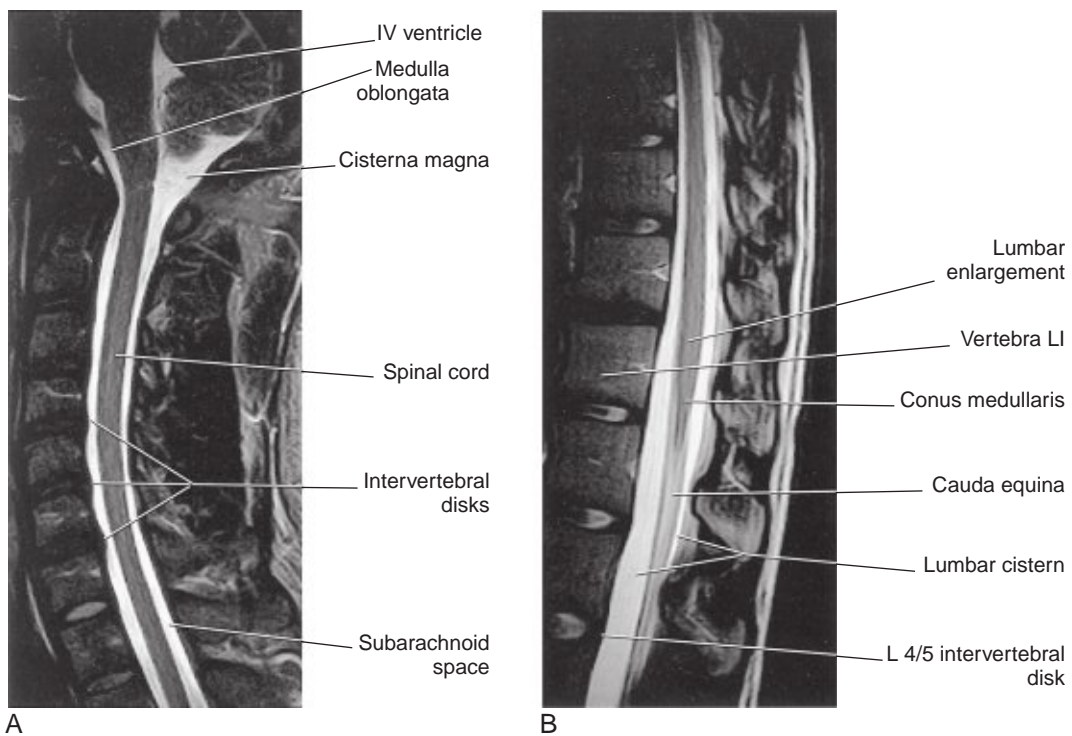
Sagittal MRI scans of the vertebral canal, weighted so as to enhance cerebrospinal fluid. (A) The brainstem, cerebellum, and cervical spinal cord are outlined. (B) The lumbosacral spinal cord and cauda equina are outlined. (From a series kindly provided by Professor J. Paul Finn, Director, Magnetic Resonance Research, Department of Radiology, David Geffen School of Medicine at UCLA, California.)
